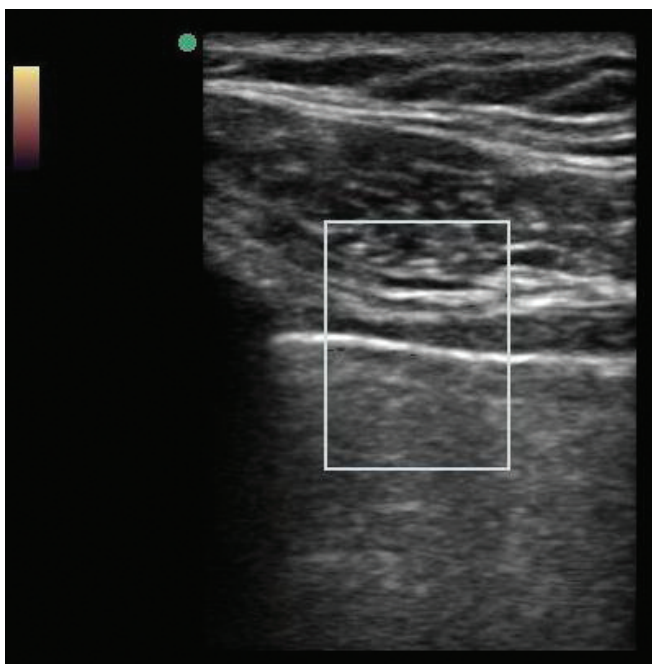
Power Doppler visualisation of pneumothorax
